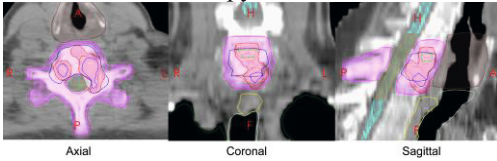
An example of the delineation of targets and OARs defined on ¹⁸F-NaF PET/CT image. MATV1: blue; MATV2: green; GTV_{reg}: dark blue; CTV_{reg}: light green; PTV_{reg}: magent; PTV_{MATV}: red; Spinal cord: cyan; Partial spinal cord: orange; Esophagus: yellow; Trachea: light green; Larynx: brown; Lung: dark green. Abbreviation: A: anterior; P: posterior; L: left; R: right; H: head; F: feet.
